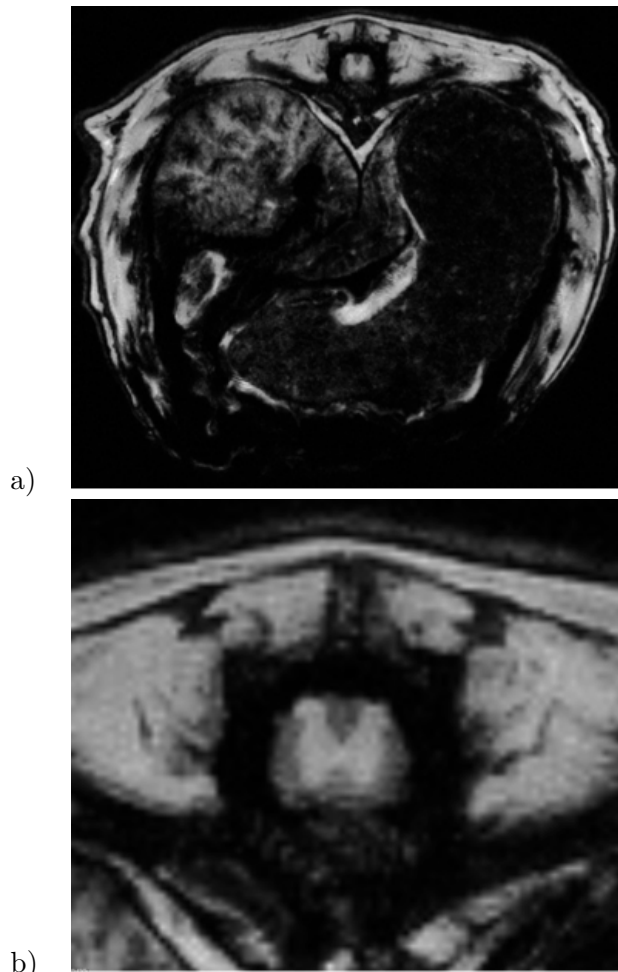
A) MRI obtained with GEMS sequence; B) Image showing the spinal cord area.
